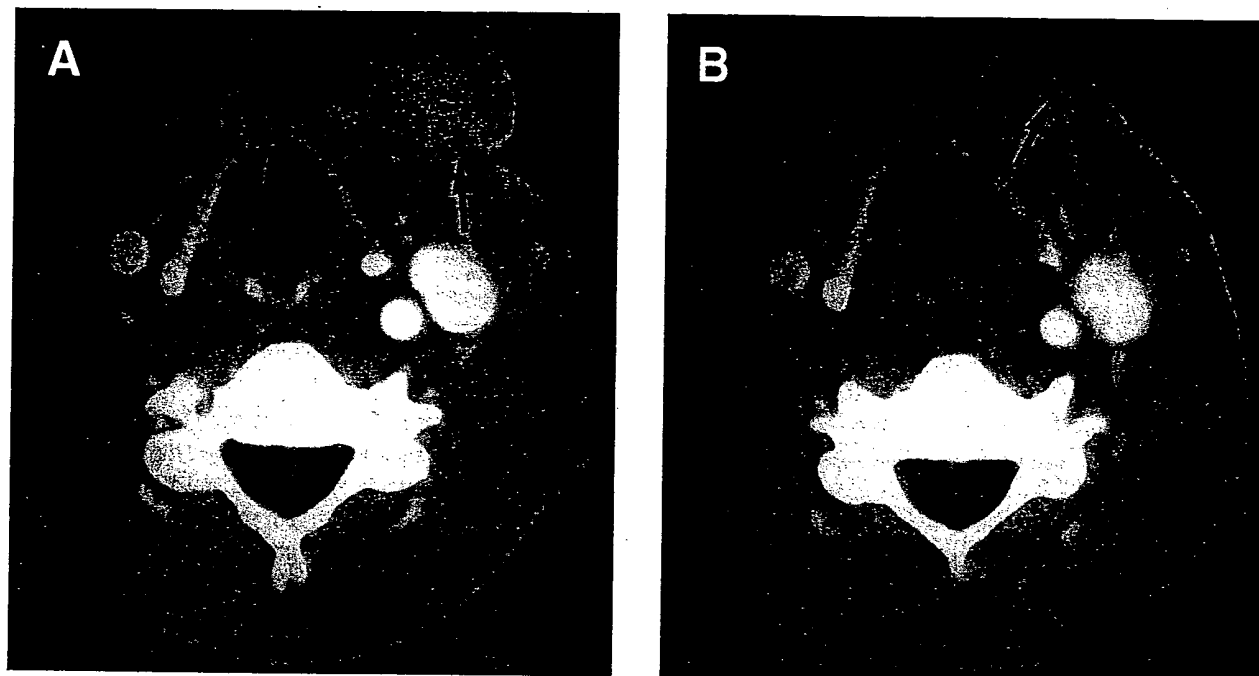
Axial post-contrast CT images (before and after 6 doses of  $10^{11}$  pfu) in patient 30, with recurrent squamous cell carcinoma and previous bilateral neck dissections. (A) Pretreatment, left-sided metastatic dermal implant (arrow). (B) Posttreatment,  $> 50\%$  tumor reduction (arrow).
